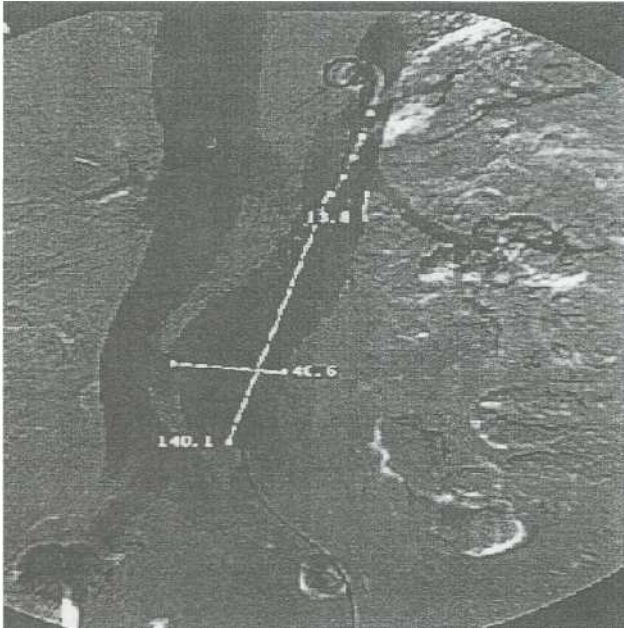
Preoperative abdominal computed tomography showing a large abdominal aortic aneurysm and aortocaval fistula
